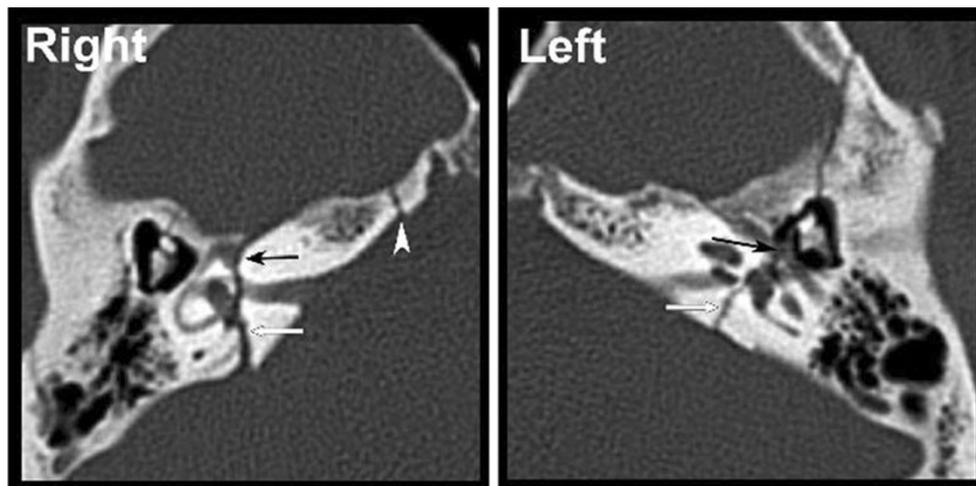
Right and left axial petrous temporal bone CT. Right axial CT shows a medial subtype of horizontal temporal bone fracture. There is a fracture of the posterior petrous surface (*white arrow*) extending anteriorly through the fundus of the internal auditory canal to the geniculate fossa of the facial nerve (*black arrow*). Separate fracture through the petrous apex indicated by *arrowhead*. Left axial CT shows
